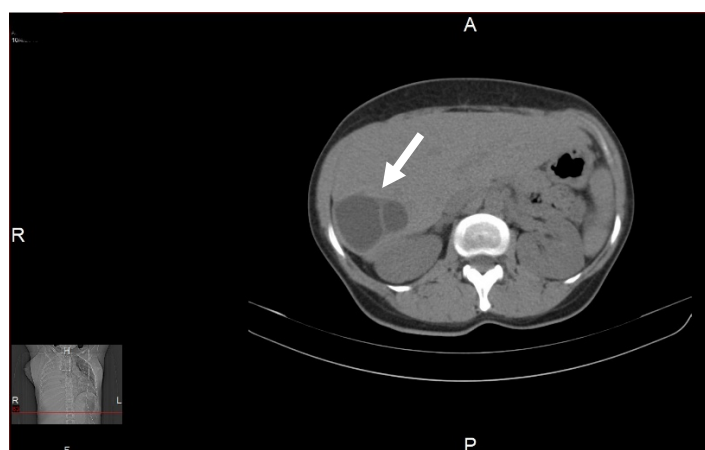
Chest computed tomography and upper abdomen scan showing cystic formation in segment VI of the liver (arrow).
